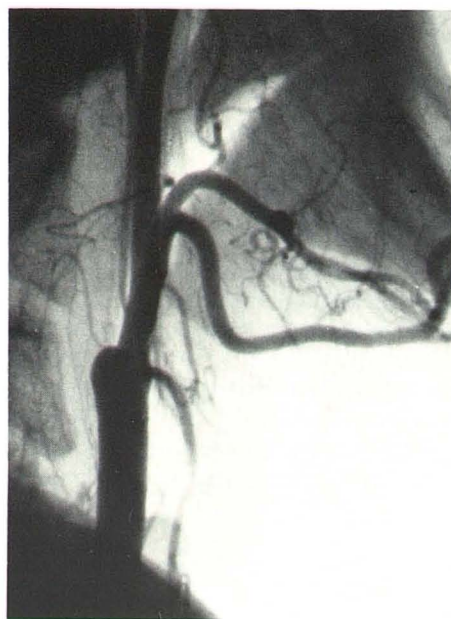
Abnormal peak velocity (blue) at origin of left internal carotid artery on Doppler scan (C) corresponds to area of stenosis on contrast angiogram (B). Plaque at origin of right internal carotid artery on contrast angiogram (A) is not large enough to increase peak systolic velocity above normal limits on Doppler scan (C).
